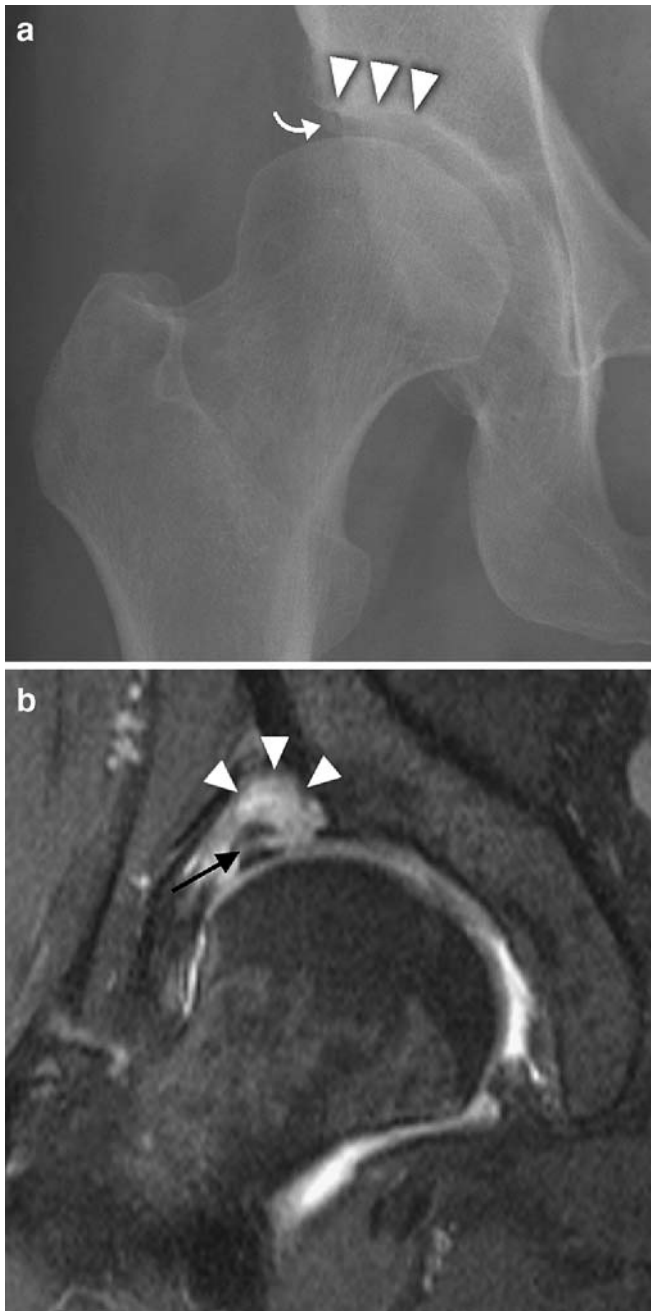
Hip dysplasia with labral tear and paralabral ganglion. a Anteroposterior view of the right hip joint shows a mild dysplasia with insufficient acetabular coverage of the femoral head (*arrowheads*) and an os acetabuli (*curved arrow*). b On the coronal fat-suppressed T2-weighted images a large detached labrum with a horizontal tear (*black arrow*) and a paralabral ganglion cyst is visible (*arrowheads*)
